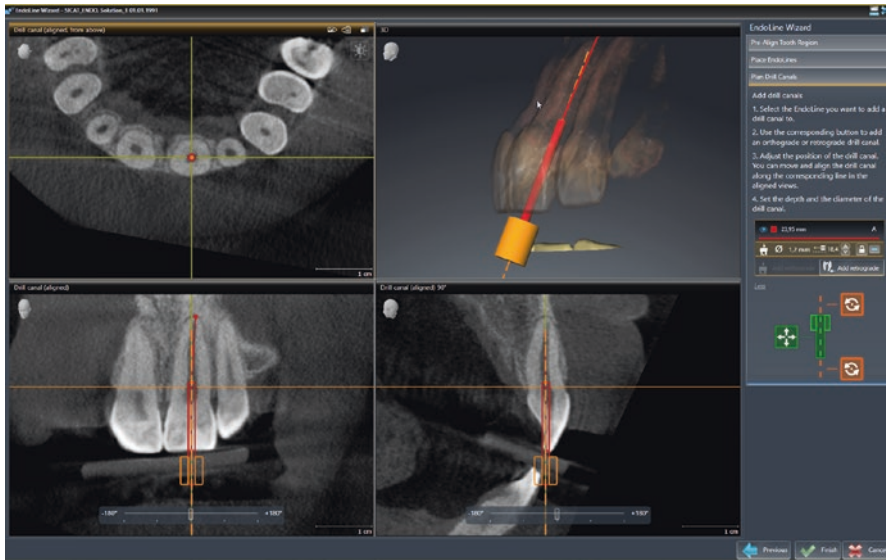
Virtual planning of microguided access. The virtual copy of the drill is positioned so that the tip reaches the radiographically visible part of the canal. Images from SICAT Endo® (SICAT, Bonn, Germany)
